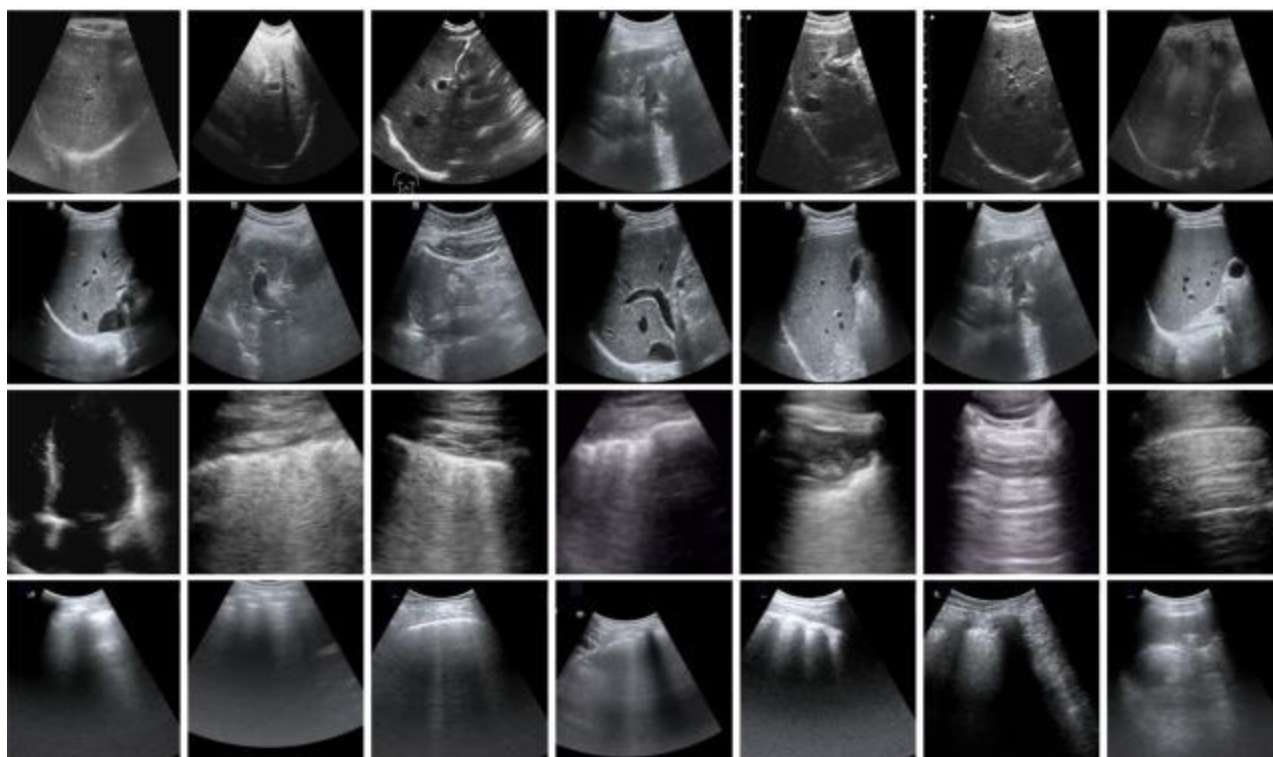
Sample test photos from the medical ultrasound dataset.
